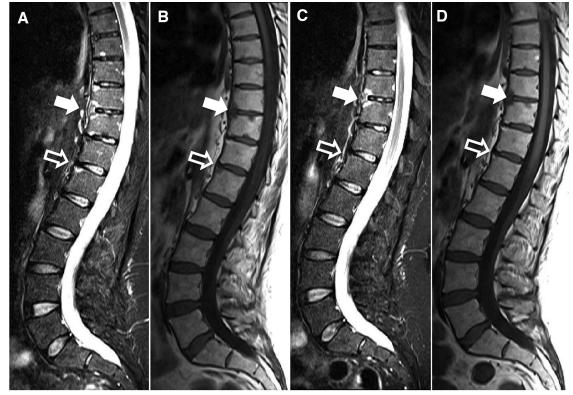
STIR-weighted and T1-weighted MRI of the lower spine at baseline and after 2 years of followup. Both possibilities of the course of inflammation with erosion can be detected: inflammation with erosion at baseline that becomes inactive after 2 years (white arrow), and inflammation with erosion at baseline that remains active after 2 years (black arrow).
